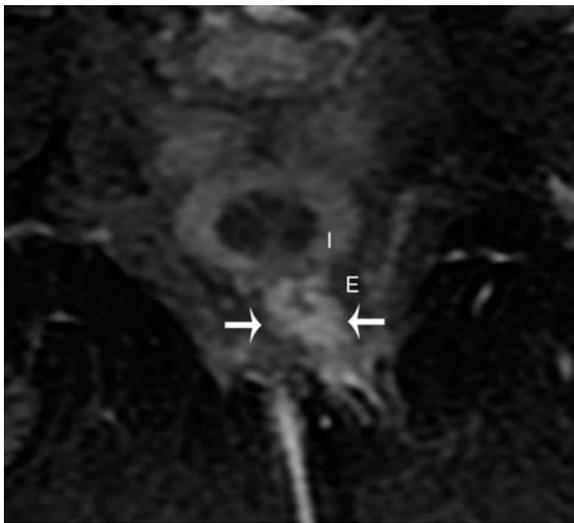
Active transsphincteric fistula in a 36-year-old male. Axial contrast-enhanced T1-weighted image with fat saturation demonstrates thick wall enhancement of a fistula (arrows) extending through both the internal (I) and external (E) anal sphincter muscles.
